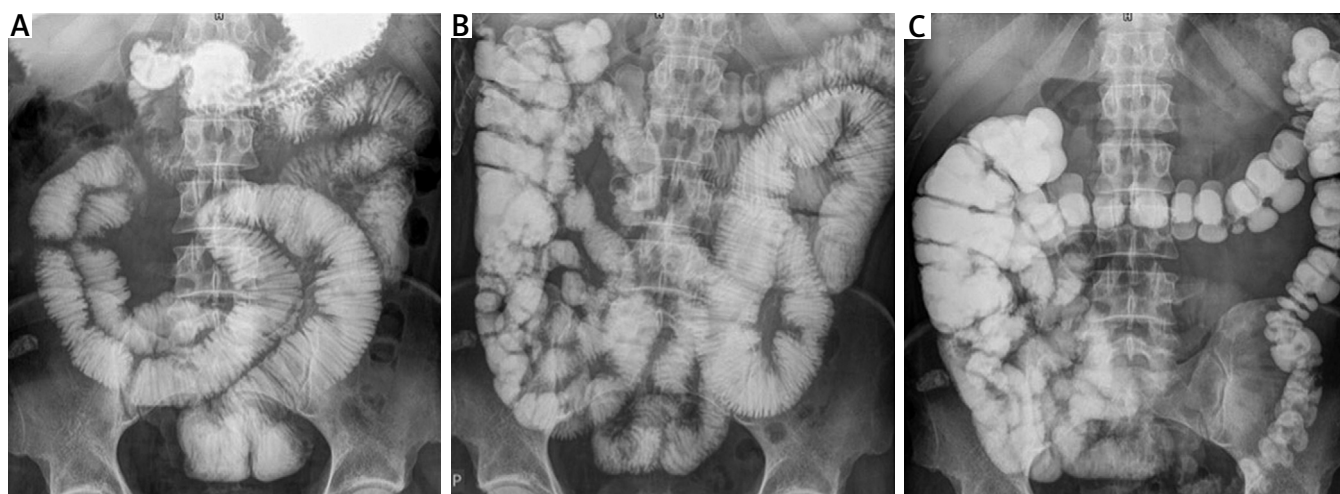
Intestinal follow-through (radiography with barium based oral contrast) showing no signs of obstruction: A) stomach and jejunum, B) ileum and colon, C) colon.
